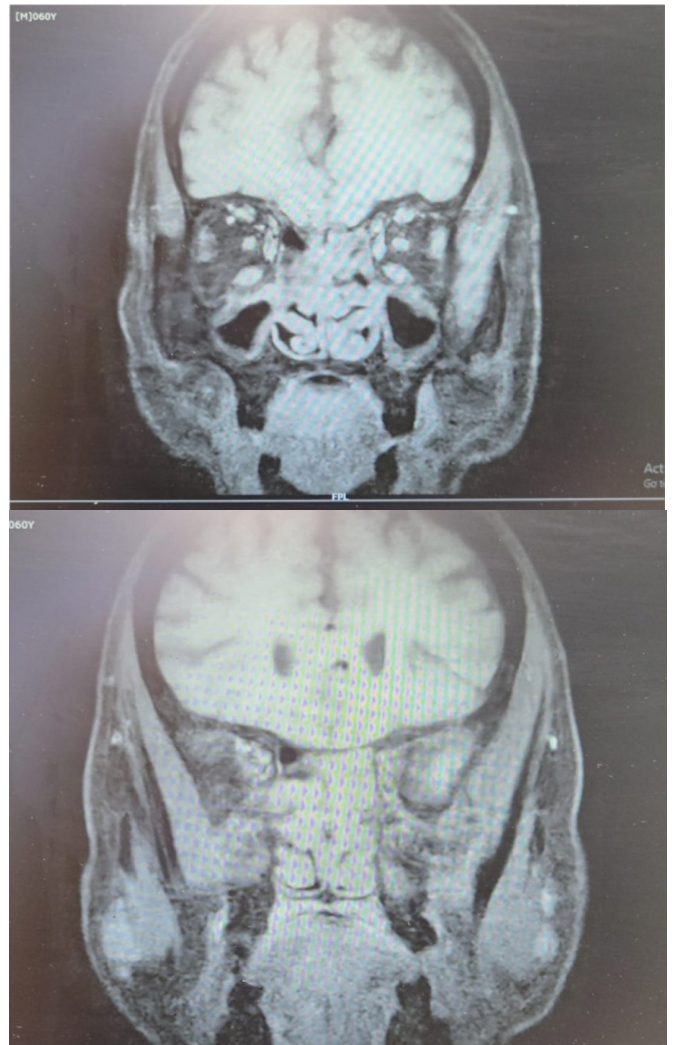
MRI showing features of pan-sinusitis
